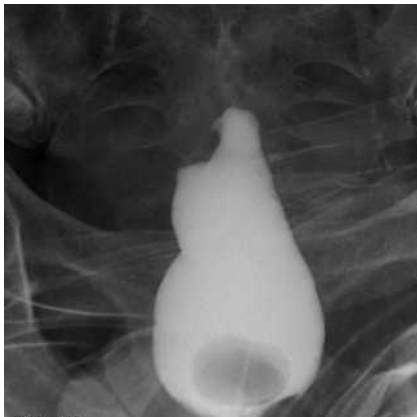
Radiograph showing no lumen at all in the anastomosis on transanal water-soluble enema.
